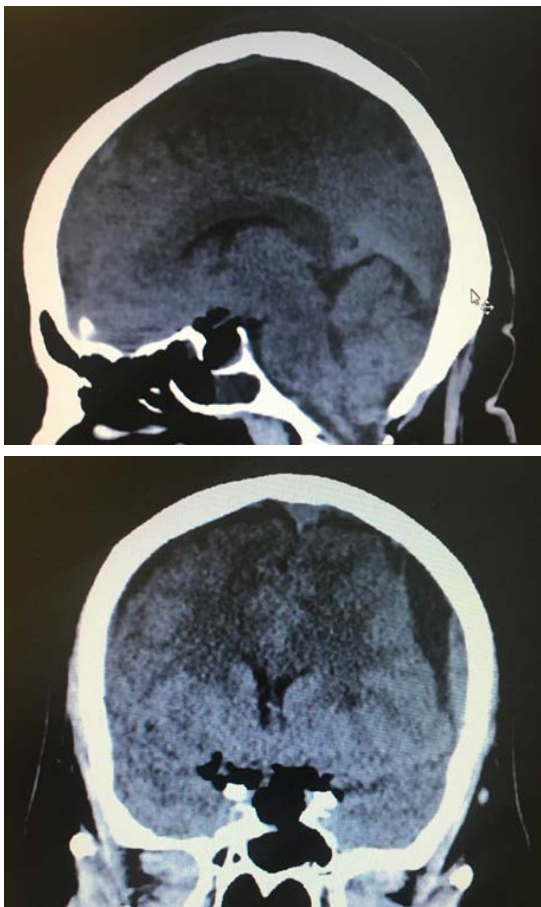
Defect in the base of skull and sphenoid sinus in the patient's CT scan.
